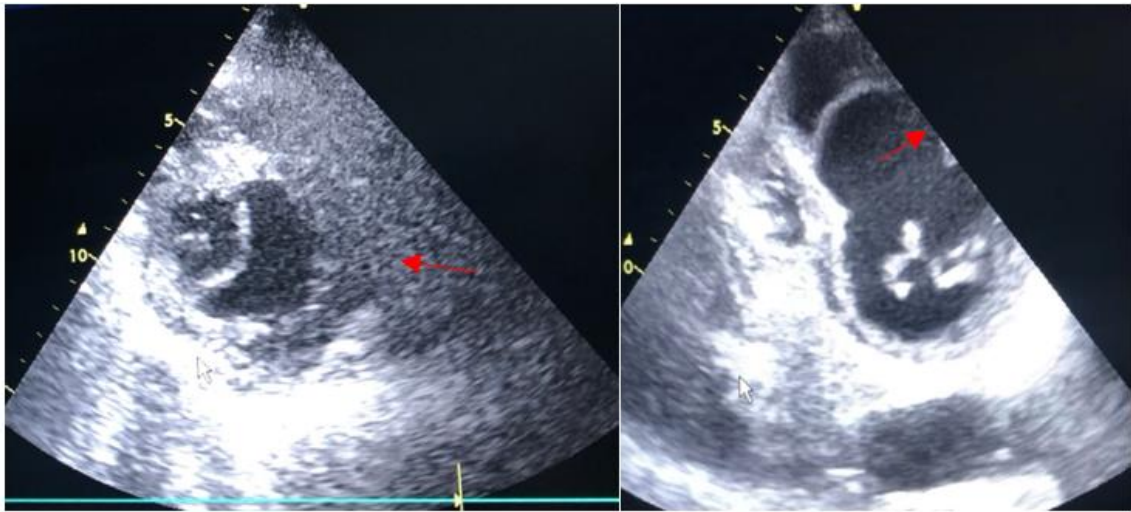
This 84-year-old patient was admitted with STEMI anteriorly. Echocardiography showed segmental hypokinetic heart disease with severe LV dysfunction (30%), a thickened, pulsatile LV cavity with dyskinetic motion, surrounded by a thin endomyocardial membrane in association with a haematoma secondary to intra-myocardial rupture.
